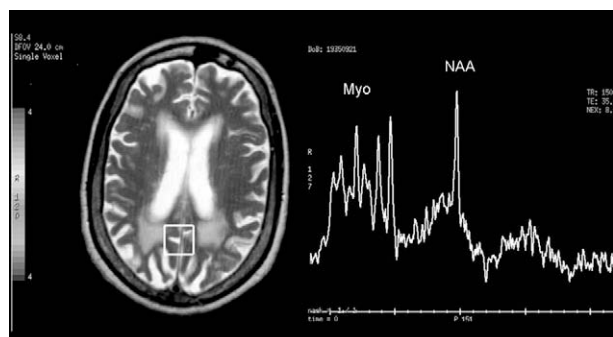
An elderly patient with increasing memory loss. (a) Axial T2-weighted image showing cerebral atrophy, as well as some periventricular T2 signal change, in keeping with some microvascular disease. (b) Short echo (TE 35 ms) MRS of the parietal grey matter demonstrating decreased NAA and increased Myo in keeping with Alzheimer's dementia.
